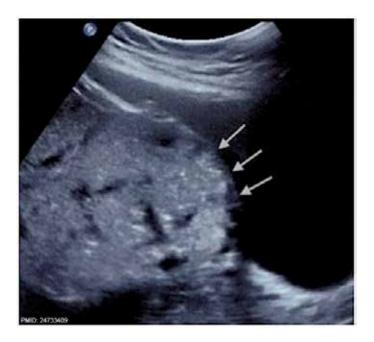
Sonogram demonstrating numerous vascular lacunae (arrows) within the placenta in a patient with placenta accreta Ultrasound of placenta and bladder wall interface indicating placenta accreta. Courtesy of Riteau et al.
